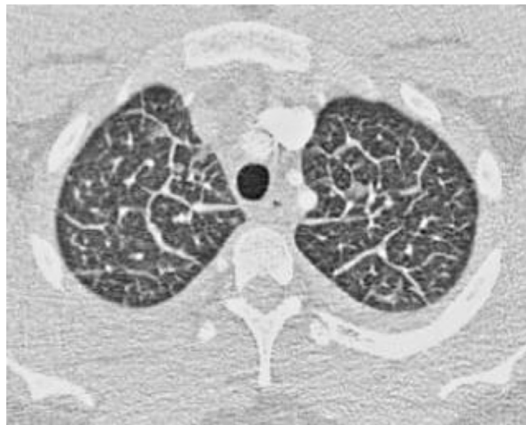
Thoracic CT presenting regular septal thickening and ground-glass opacities.
